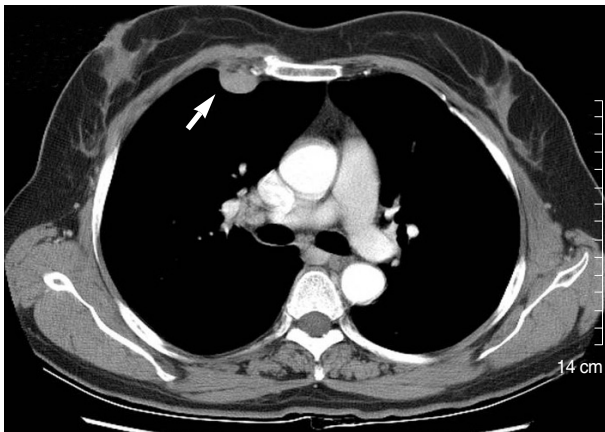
CT scan of the chest. A 3 cm sized mass is present in right middle lobe of the lung (arrow) with an irregularly thickened adjacent pleural surface.
